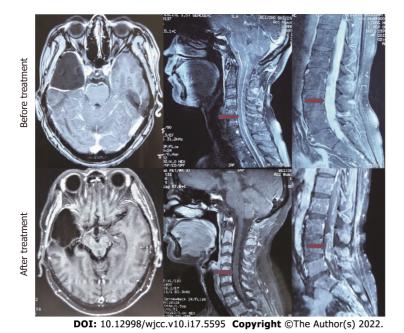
Magnetic resonance imaging scans (T1 + gadolinium) of a patient before (upper panel) and after 4 cycles of vp-16 + CBP chemotherapy combination with methotrexate intrathecal injection (lower panel). The lesion in the right temporal lobe was stable after surgery. The multiple lesions in the cervical (middle column, red arrows) and lumbar (right column, red arrows) spine went into remission.
